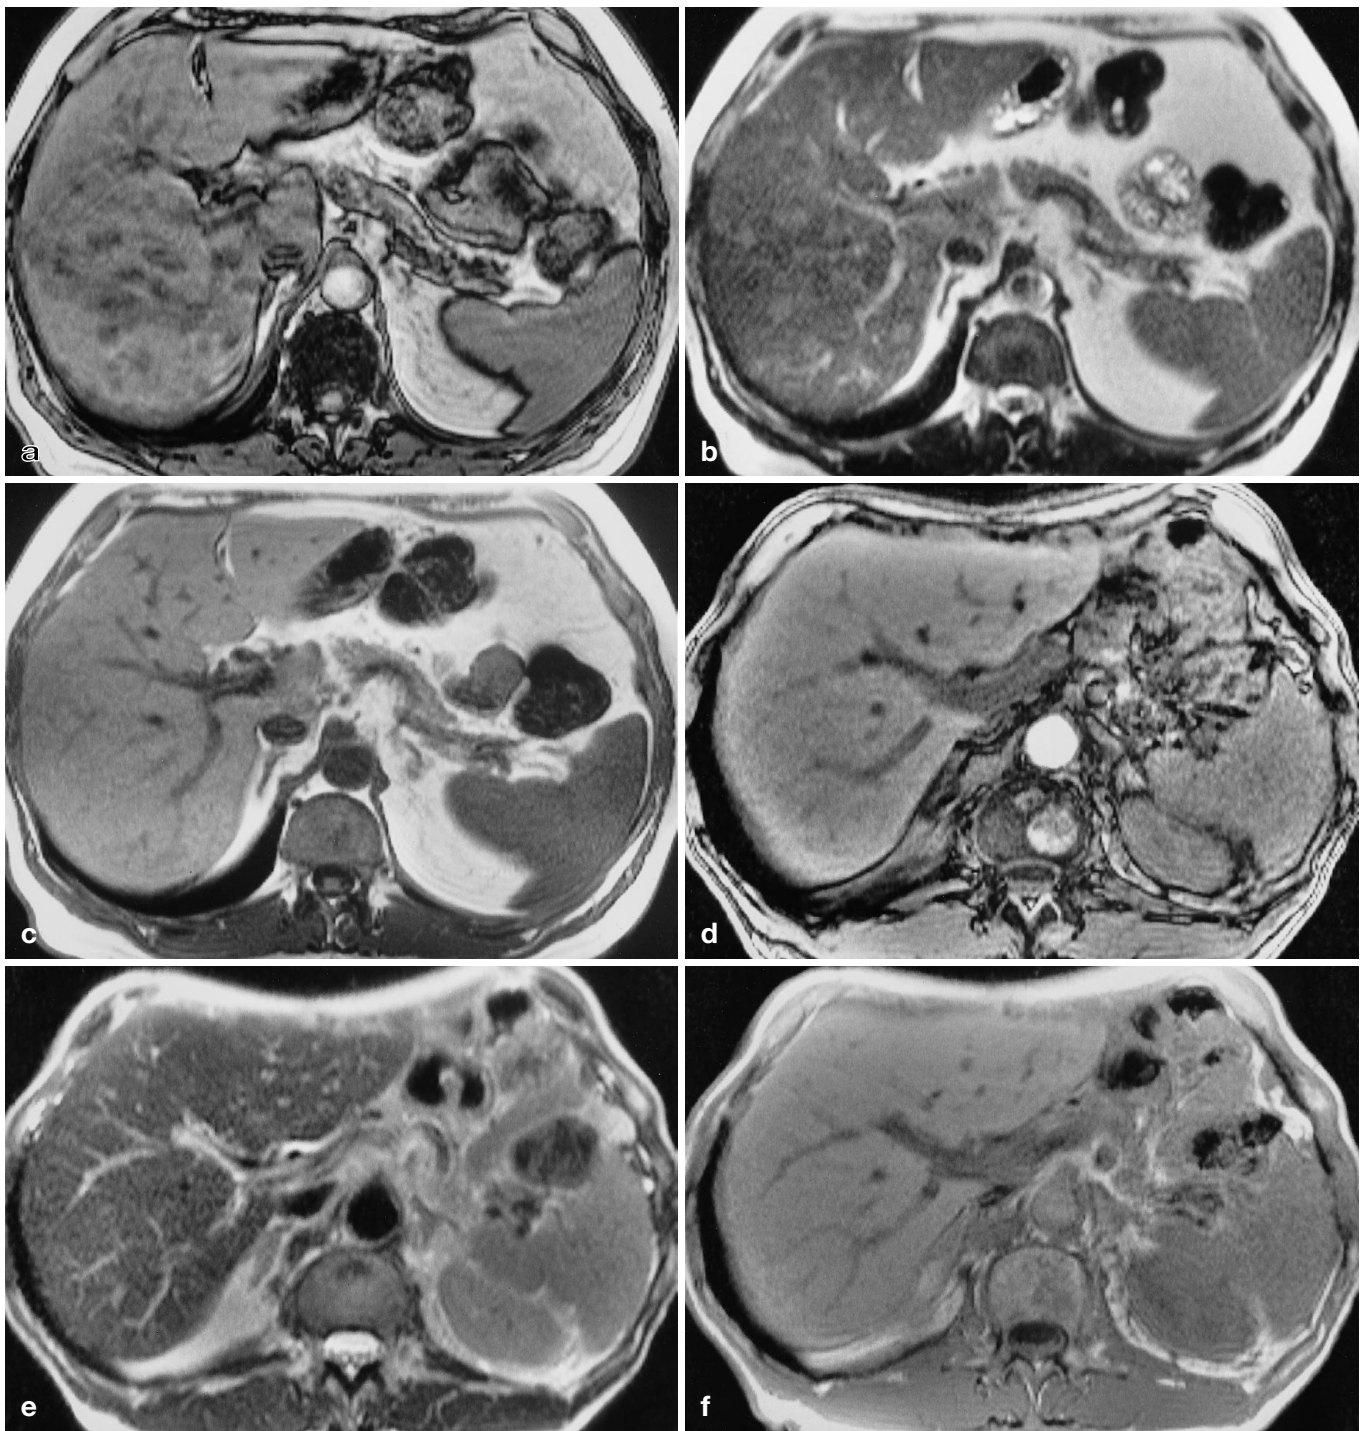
Magnetic resonance images of a 59-year-old patient with gastric cancer (not shown) and marked obesity. a On T1-weighted GRE opposed-phase images multiple nodular hypointense lesions are present. b On T2-weighted HASTE images the lesions are hyperintense. c T1-weighted GRE in-phase images do not show any lesion. Follow-up MR imaging was performed after gastrectomy and a 1-year interval between both exams. A marked reduction in body weight is seen by comparing the thickness of the subcutaneous fat layer on both exams. d On T1-weighted GRE opposed-phase and on e T2-weighted HASTE images, as well as f T1-weighted GRE in-phase images, no lesions are detectable, demonstrating resolution of benign MNFIL
